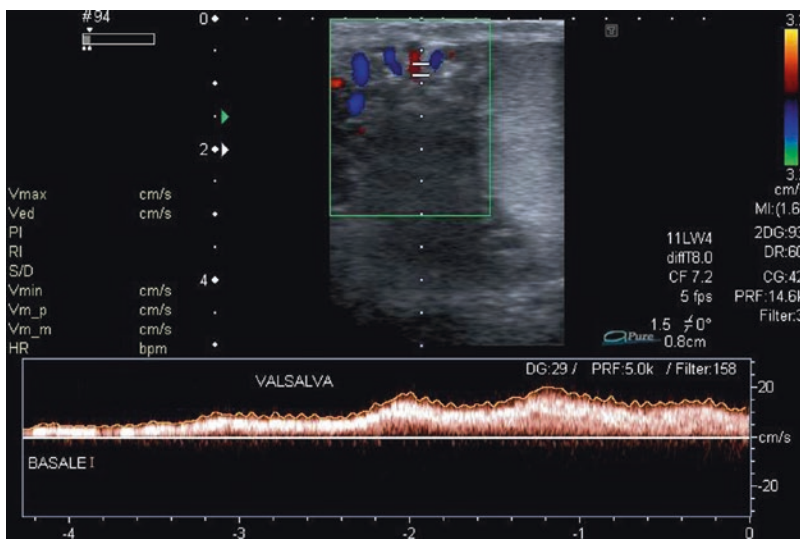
Spectral Doppler analysis in varicocele showing a reflux during Valsalva lasting approximately 5 s
